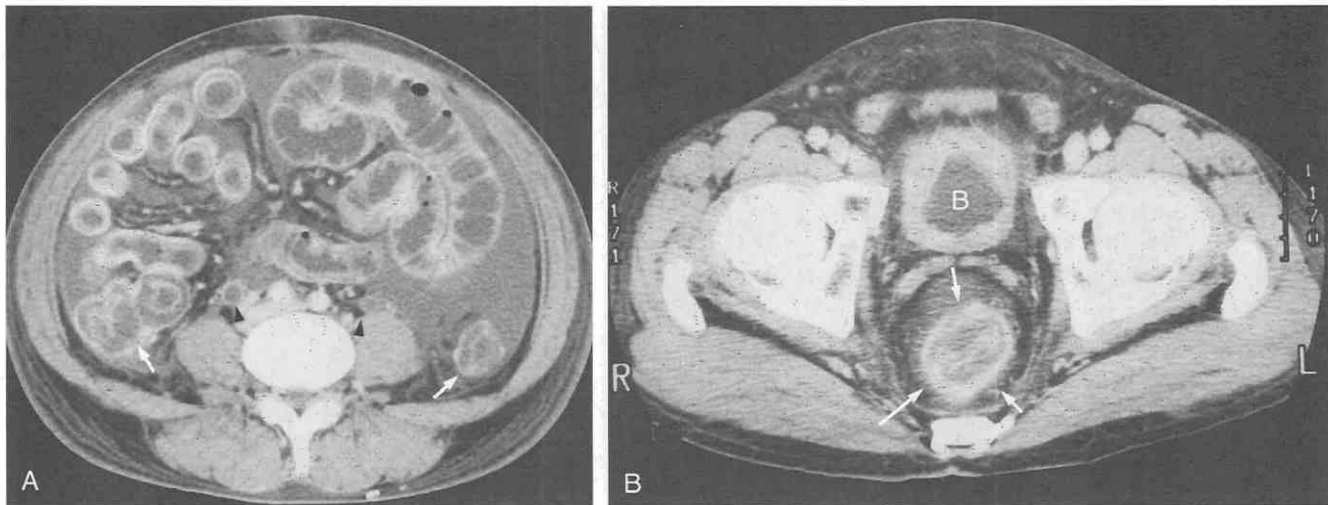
Polyarteritis nodosa. A, CT scan shows bowel wall thickening of the ileum and ascending and descending colon (arrows) with evidence of the “target sign.” Also noted are a large amount of ascites and bilateral ureteral dilatation (arrowheads). B, CT scan shows rectal wall thickening (arrows) with the target sign. The bladder (B) is also diffusely thickened. (From Ha HK, Lee SH, Rha SE, et al: Radiologic features of vasculitis involving the gastrointestinal tract. *Radiographics* 20:779–794, 2000.)
